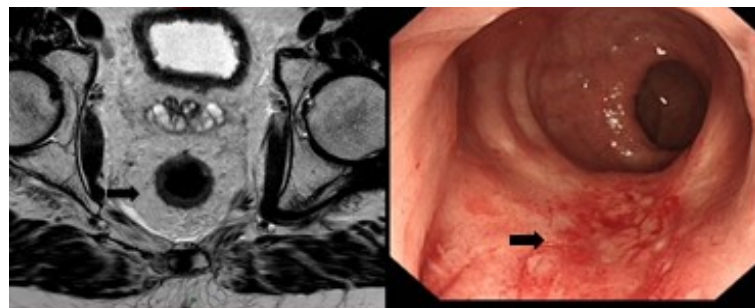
Baseline MRI pelvis and endoscopy with tumour indicated by white arrow
